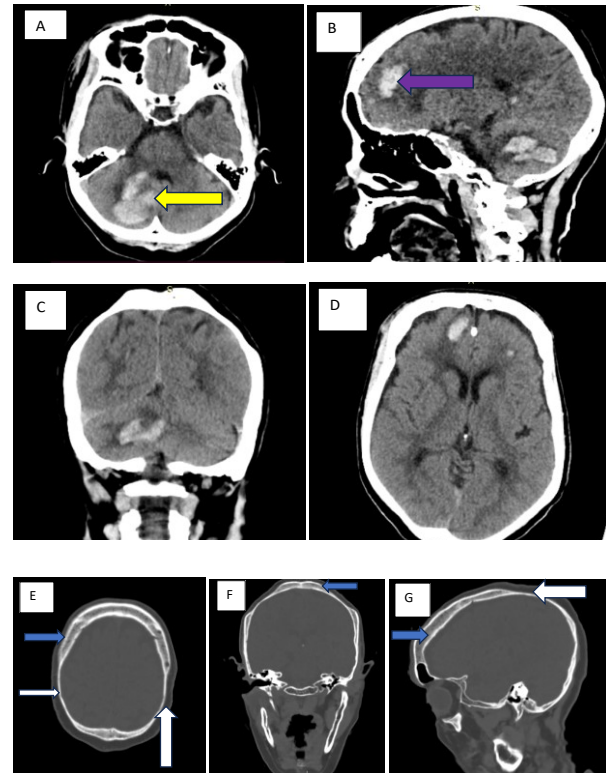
(Cranial computed tomographic images in brain windows (A-D), showing hyperdense collections (HU=62) consistent with right cerebellar hematoma (yellow arrow) and right frontal lobe contusion (purple arrow) and in bone windows (E-G) which show bilateral and symmetrical thinning of the parietal bones (white arrows) with preservation of other bones (blue arrows) of the skull.
